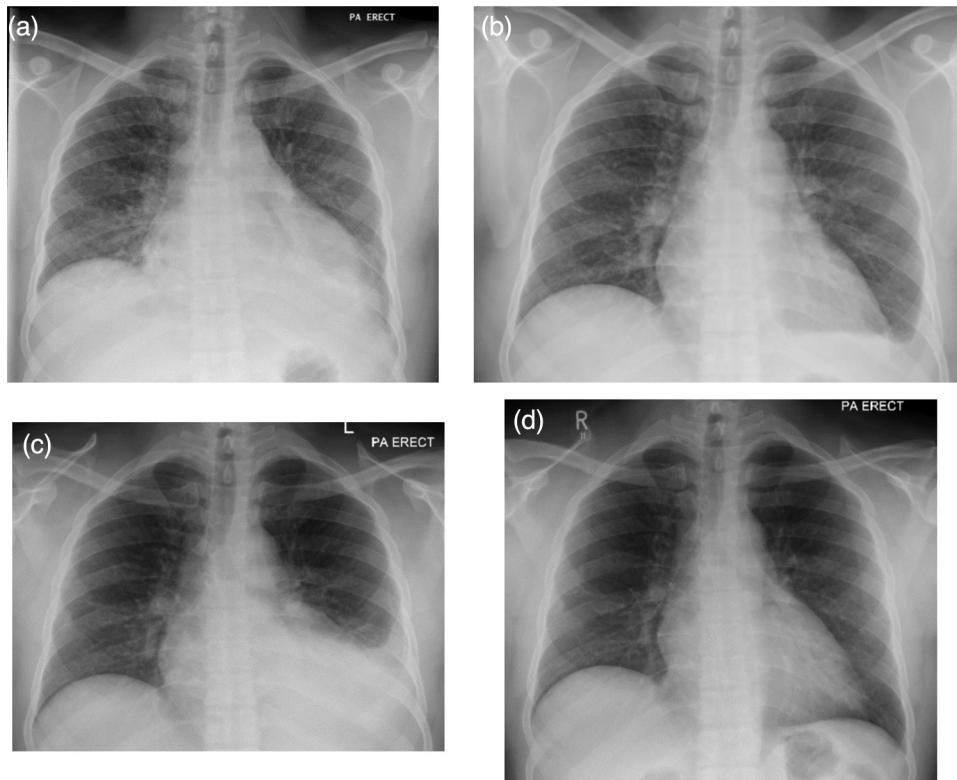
Chest X-rays (CXR) demonstrating radiographic features of a paradoxical reaction in an HIV-negative male with pericardial and miliary drug-sensitive tuberculosis (TB). (a) CXR at presentation showing an enlarged heart and lung nodules; the patient commenced antimycobacterial therapy and corticosteroids. (b) CXR at 2 weeks after the commencement of treatment (when the patient was feeling better) revealing radiographic improvement. (c) CXR at week 5 (patient reported a slight increase in breathlessness) showing deterioration with cardiac enlargement and worsening left pleural effusion; anti-TB therapy was continued and the corticosteroid dose was increased. (d) CXR at week 10; the patient was feeling better and the chest radiograph shows considerable improvement.
